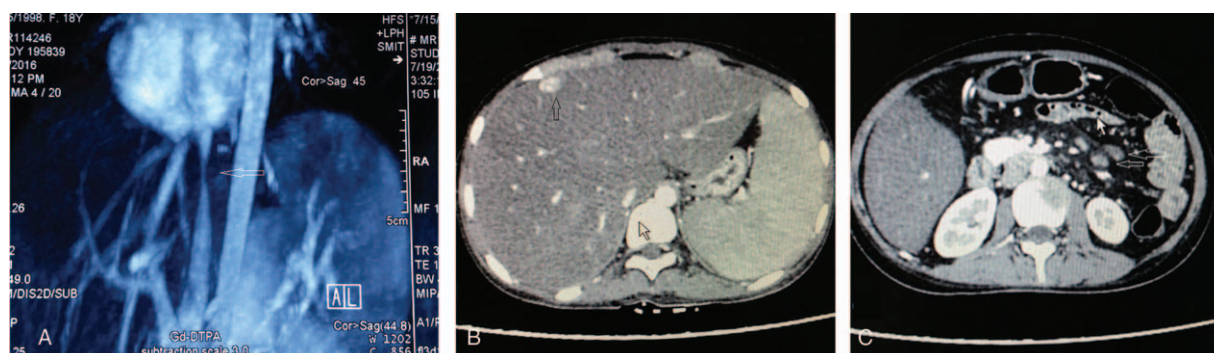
(A) Computed tomography vein imaging showed compressed constrictive inferior vena cava (arrow). (B) Decreased liver density and hepatosplenomegaly, strengthen intrahepatic nodules (arrows). (C) Lymphadenectasis around the mesenteric root (arrows).
